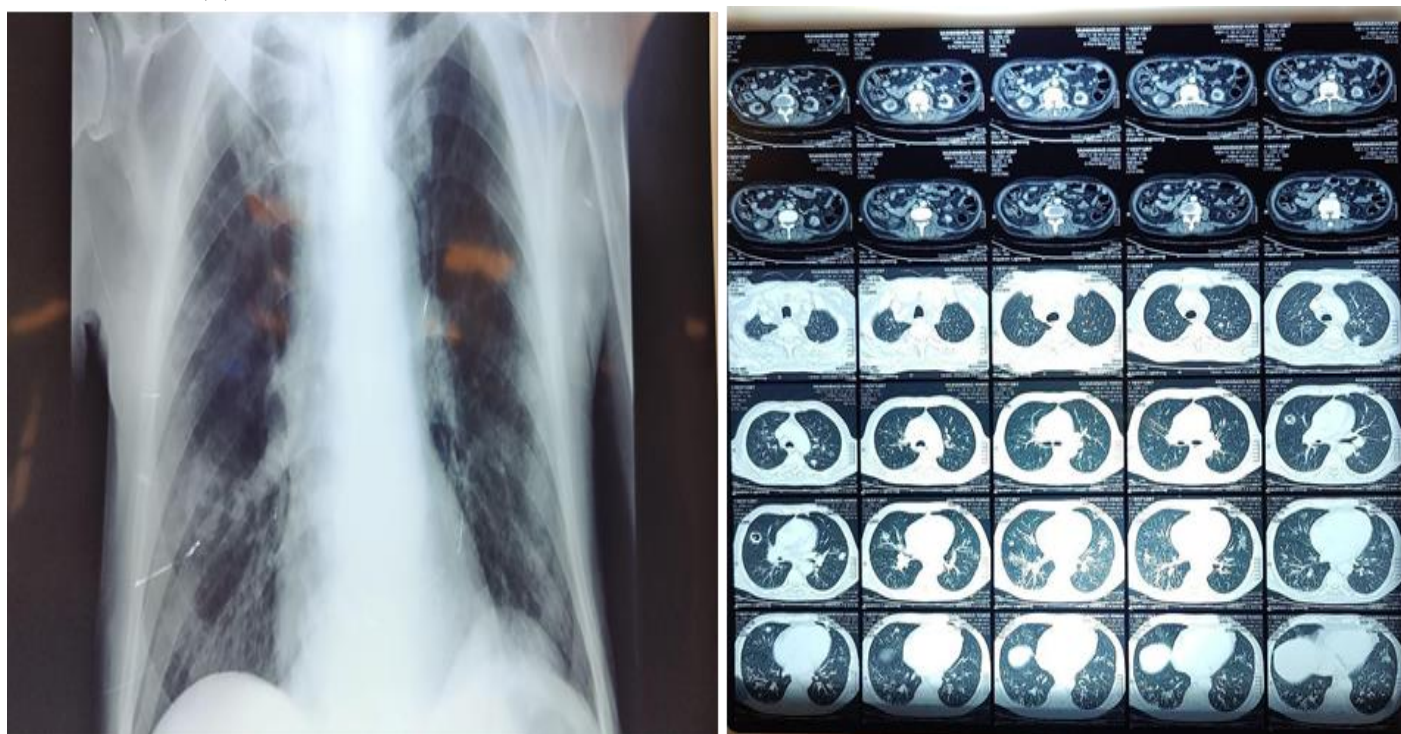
X-ray chest PA view and Computed Tomography of patient presenting with Aspergillosis after renal transplant
